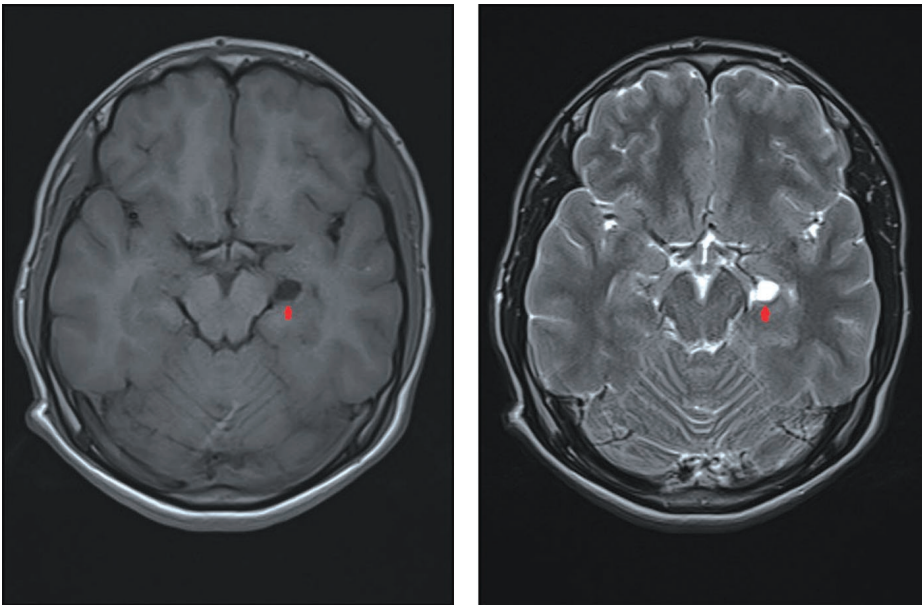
MRI image of arachnoid cyst (axial section T2 weight-axial section T1 weight)
